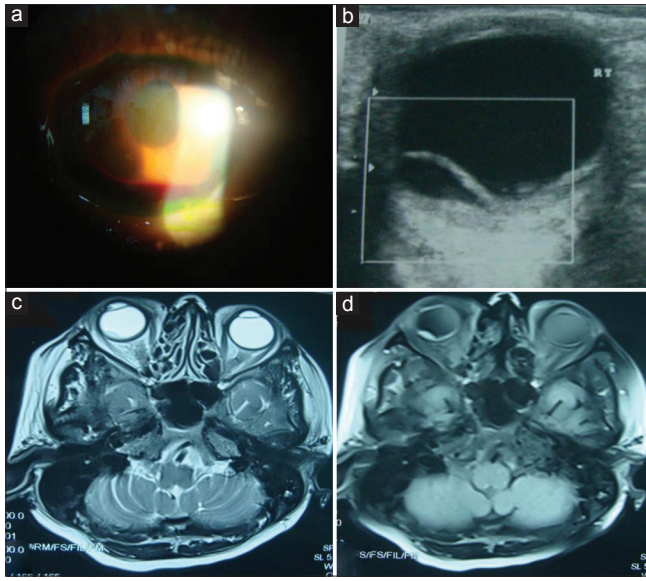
(a) Anterior segment image of the right eye showing hyphema, thin fibrinous reaction at pupillary area, and posterior synechiae at 2–6 o'clock position. (b) B-scan ultrasonography of the right eye showing retinal detachment with diffuse choroidal thickening. T2-weighted (c) and Fat-suppressed T1-weighted (d) imaging shows focal retinal detachment with subretinal exudates in the posterolateral aspects of right eye and the bilateral diffuse thickening of choroid and optic nerve sheath complexes
